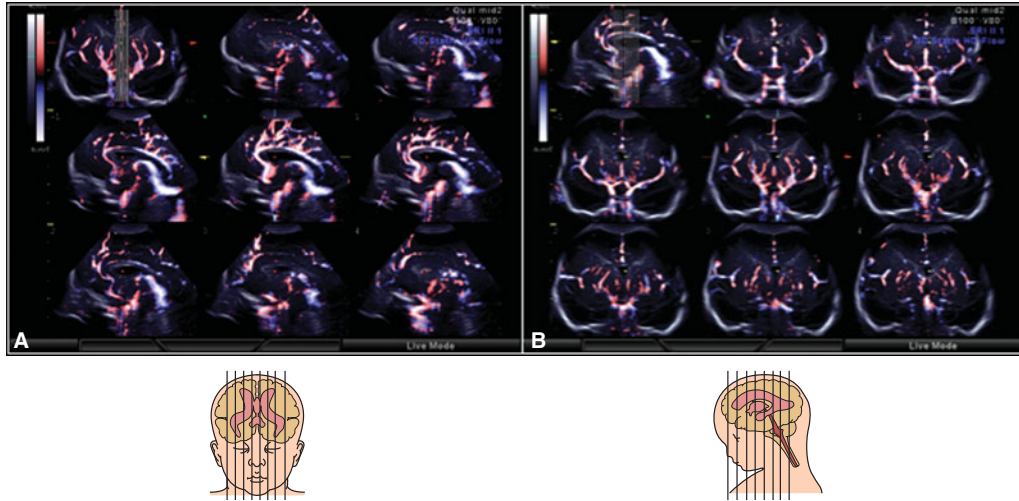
3D tomographic ultrasound (US) image of brain circulation at 31 postmenstrual weeks. (A) Tomographic power Doppler imaging of serial sagittal sections on which the anterior cerebral arteries and their branches are seen. The image at the center represents the perfect median section. (B) Successive and serial coronal sections. The middle cerebral arteries and their branches are seen on these sections.
